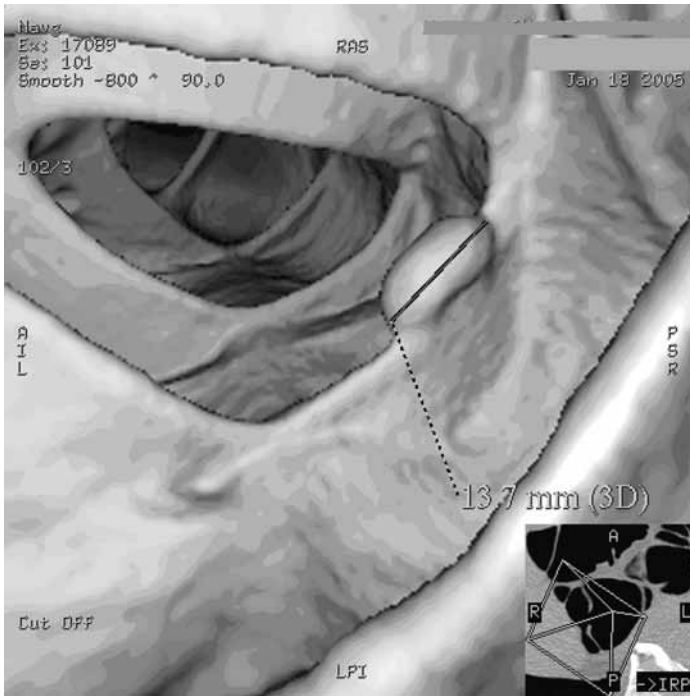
Computed tomography colonographic multiplanar reformatted three-dimensional endoluminal image (generated on a GE Advantage 4.2 workstation) showing a 1.4 cm polyp in the hepatic flexure.
